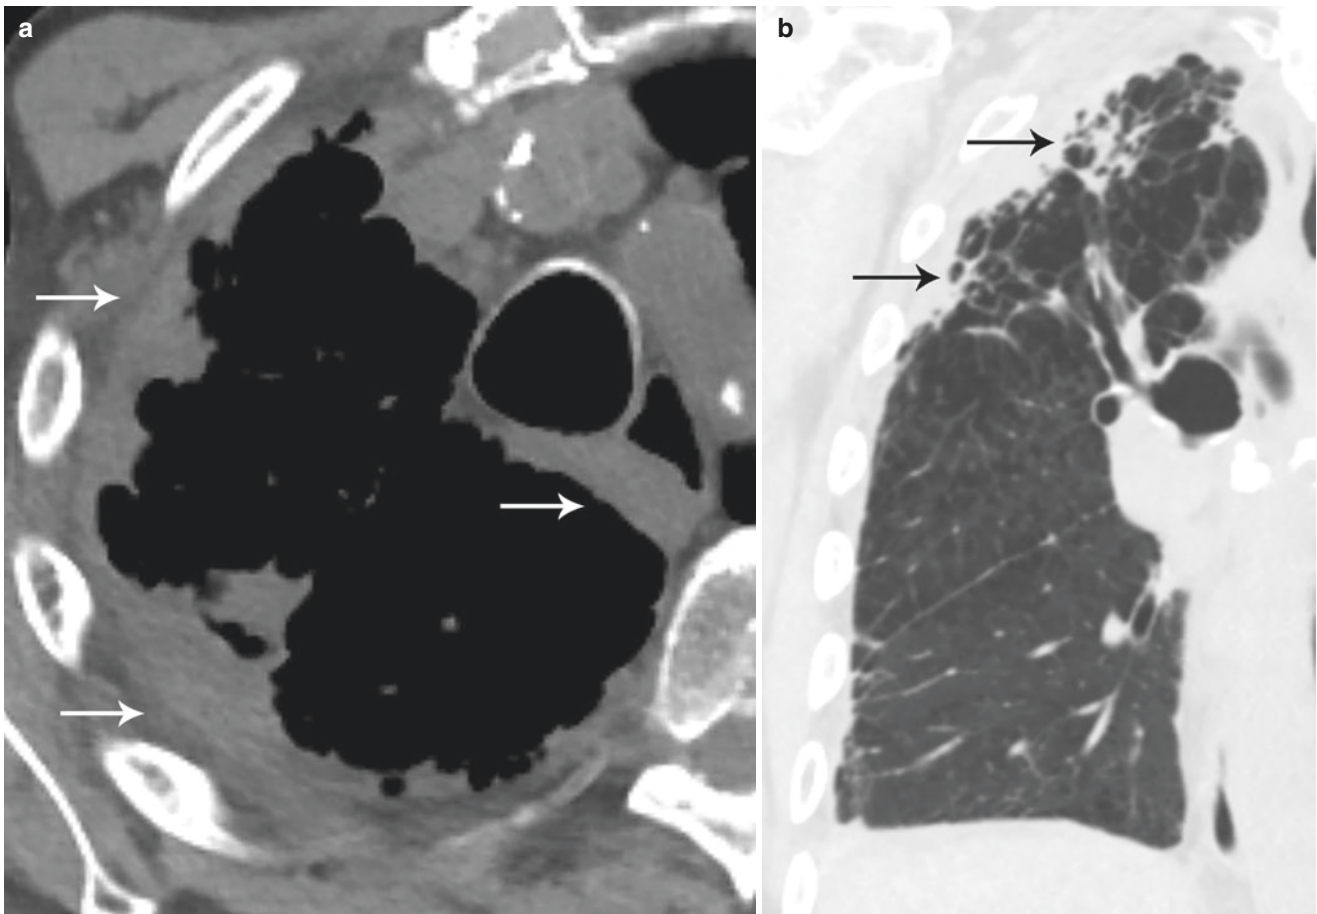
(a) Non-contrast axial CT shows the right pleural thickening (arrows) in the upper thorax; (b) non-contrast coronal CT shows reticulonodular lung fibrosis in the subpleural distribution (arrows) typical of PPFE. Note lung emphysematous changes
